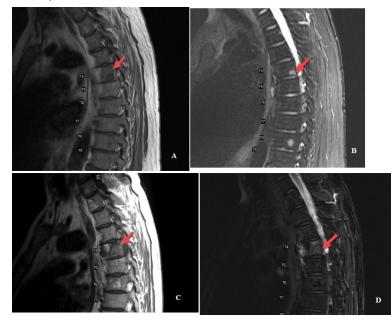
A: A 49-year-old man with metastatic myxoid liposarcoma. Sagittal T1W MRI demonstrated a low T1 signal lesion (Red arrow. B: A 49-year-old man with metastatic myxoid liposarcoma. Sagittal T2W MRI demonstrated an increased T2 signal lesion (Red arrow). C: A 49-year-old man with metastatic myxoid liposarcoma. 9 months later, Sagittal T1W MRI without contrast demonstrating an increase in T1 signal intensity with interval increase in size (Red arrow). This is an atypical pattern for a metastatic myxoid liposarcoma. D: A 49-year-old man with metastatic myxoid liposarcoma. 9 months later, Sagittal T2W MRI without contrast demonstrating an increase in T1 signal intensity with interval increase in size (Red arrow). This is an atypical pattern for a metastatic myxoid liposarcoma. D: A 49-year-old man with metastatic myxoid liposarcoma. 9 months later, Sagittal T2W MRI without contrast demonstrating an increase in T2 signal intensity with interval increase in size (Red arrow).
